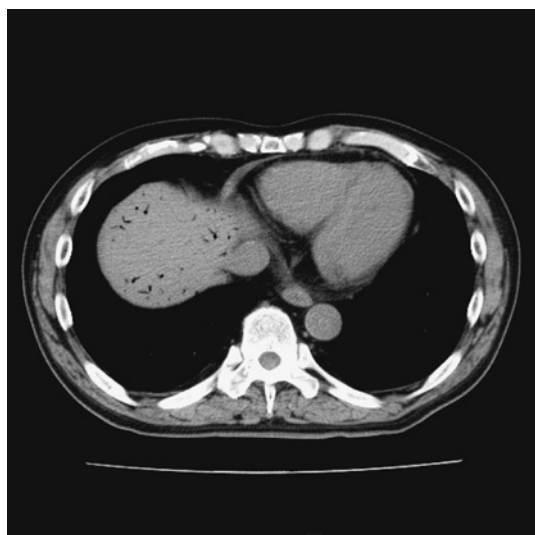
CT 5 days after the first operation
